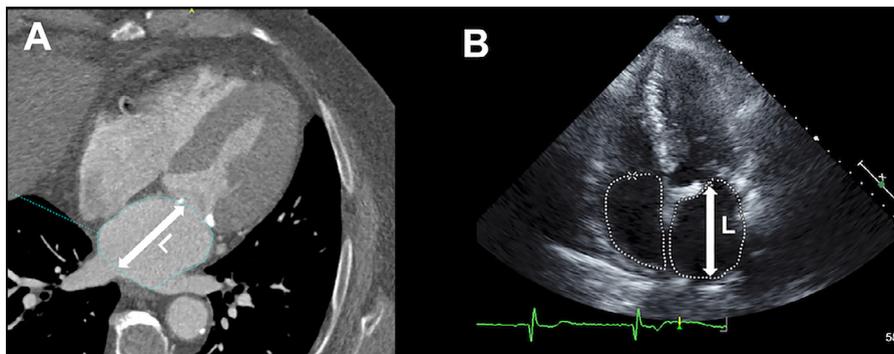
Measurement of LA volume using AL method by MDCT (A) and TTE (B). The LA area is traced from the apical 4-chamber and 2-chamber views at ventricular end-systole (maximal LA size). The length (L) is measured from the back wall to the line across the hinge points of the mitral valve. The shortest length between apical 4-chamber or 2-chamber is used in the equation. The LA volume is measured using the following equation: LA volume = $8/3\pi \times [(A1) \times (A2)/L]$. A1, the LA area traced from the apical 4-chamber view; A2, the LA area traced from the apical 2-chamber view. AL = area-length; LA = left atrial; MDCT = multi-detector computed tomography; TTE = trans-thoracic echocardiography
